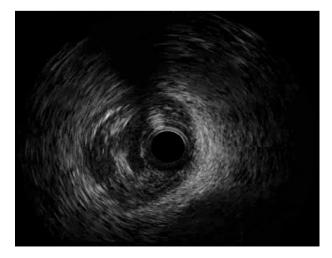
Intravascular ultrasound image showing dissection flap in right coronary artery.
